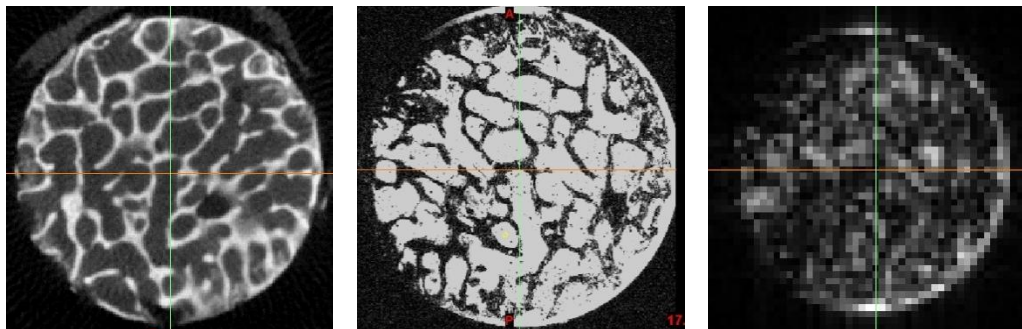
Representations of roughly the same cross section of the trabecular bone sample in μ CT (left), μ MR (middle) and whole-body MR (right).
